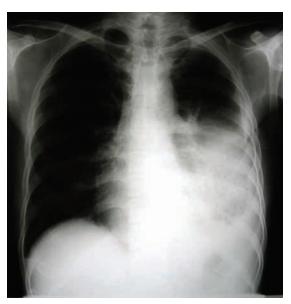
X-ray of pleural effusion.
